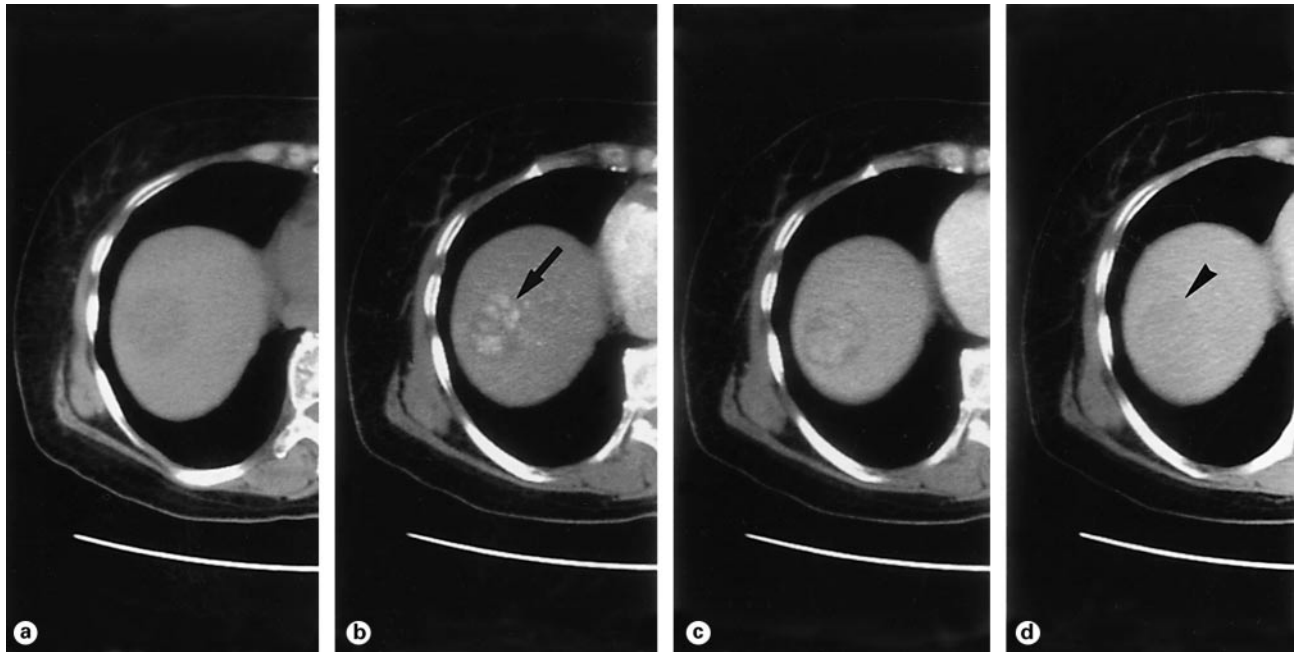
HCC in a 64-year-old woman. Unenhanced (a), arterial phase (b), portal venous phase (c), and equilibrium phase (d) images of dynamic helical CT with intravenous contrast medium injection show a hypervascular tumor. The tumor is enhanced during the arterial phase in comparison with the surrounding hepatic parenchyma (arrow). In the equilibrium phase, the tumor shows washout of contrast material and hypoattenuation compared with the surrounding hepatic parenchyma (arrowhead).
